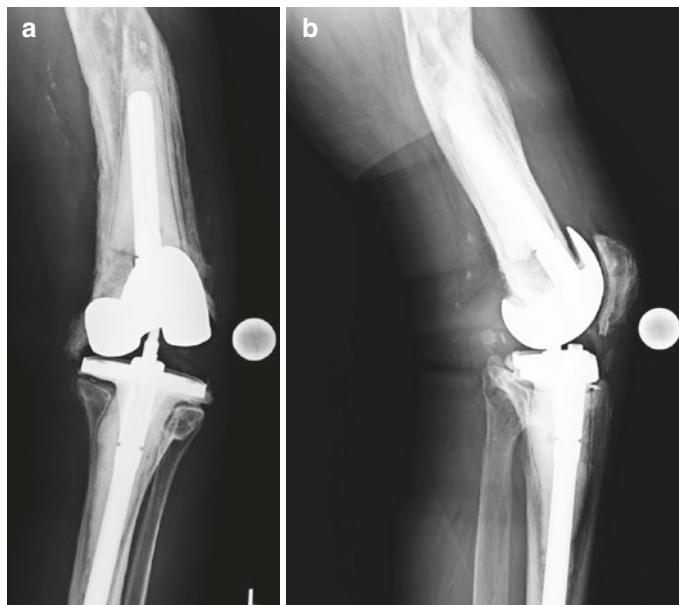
Preoperative anteroposterior (AP) (a) and lateral (b) radiographs of the patient's knee
